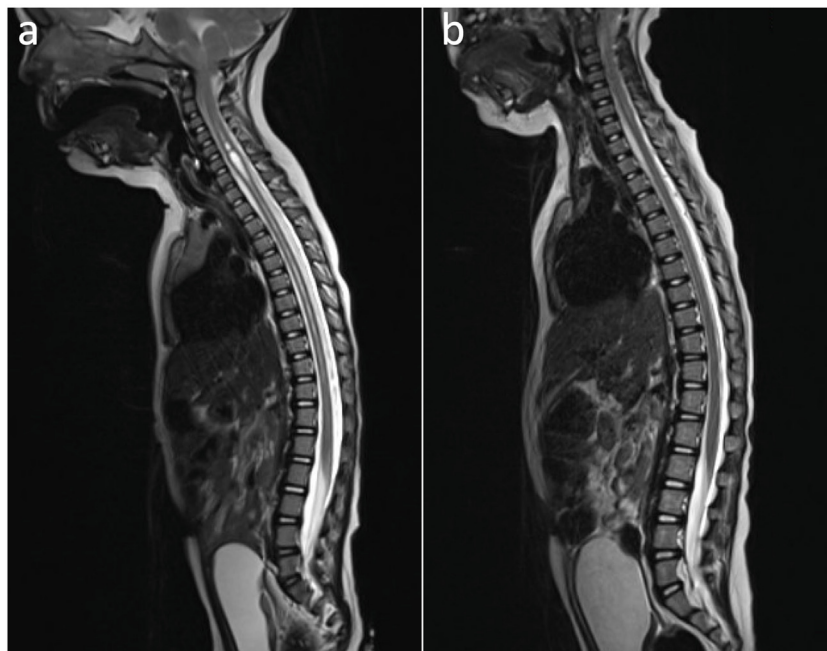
Magnetic Resonance Image (MRI) showing the resolution of the syrinx after surgery. a) Preoperative sagittal T2 sequence MRI showing tonsillar ectopia and extensive multiloculated syrinx. b) Postoperative sagittal T2 sequence MRI showing complete resolution of the syrinx.
